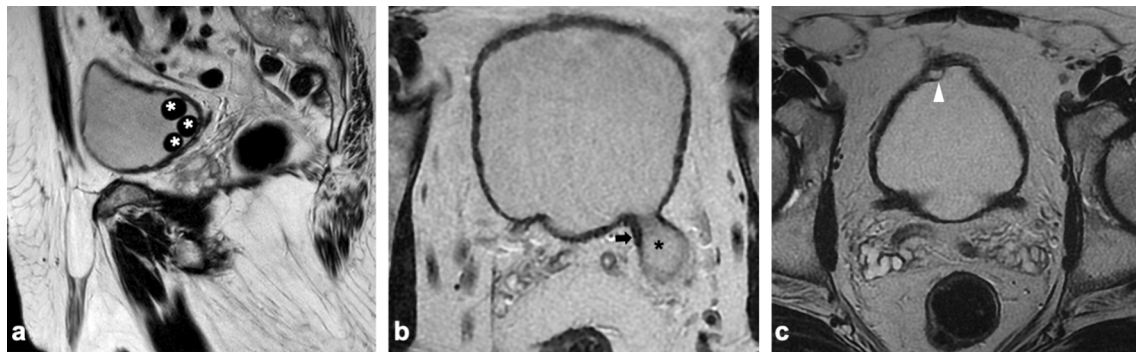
Sagittal T2w image (a) shows multiple intraluminal signal voids (white asterisks) within the hyperintense fluid in the urinary bladder, in keeping with stones. Axial T2w image (b) shows a bladder diverticulum (black asterisk) involving the left ureteral meatus (black arrow), known as Hutch diverticulum. Axial T2w image (c) shows a well-capsulated homogenous fluid-filled structure (arrowhead), adjacent to the bladder apex, at the attachment of the median umbilical ligament, consistent with urachal cyst. T2w T2-weighted.
